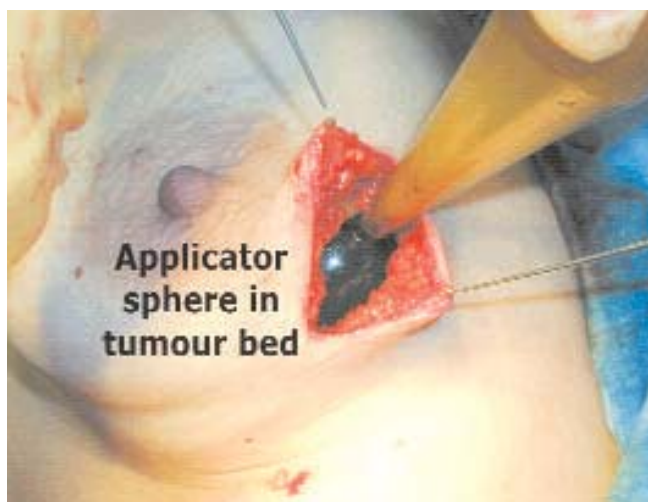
Intrabeam intraoperative soft X-rays
